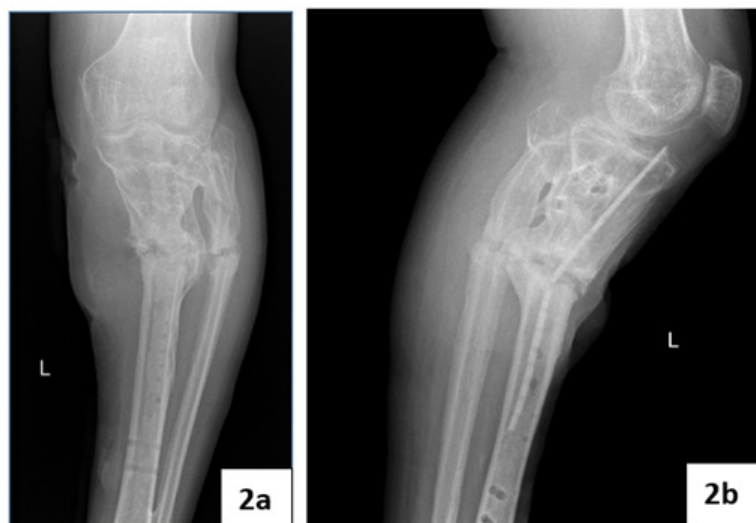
Case n° 1. Radiographs eleven years after the initial fracture. Mobile pseudarthrosis with varus deformity.
